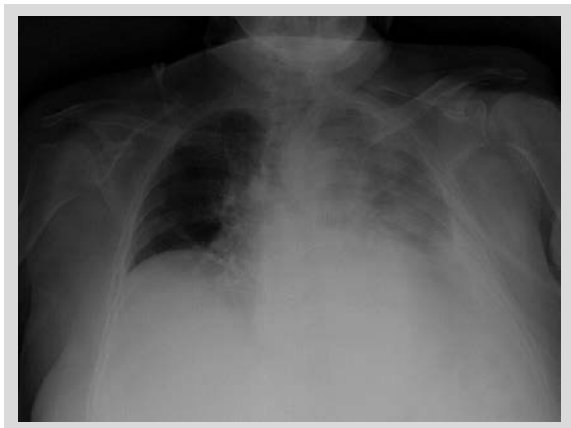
Left pleural effusion in chest X-ray of the second patient when she developed acute respiratory failure during hospitalization.
